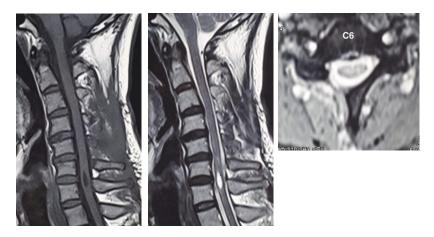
Post-operation MRI showed complete spinal cord decompression but remaining syringomyelia after taking the blood clot out.
